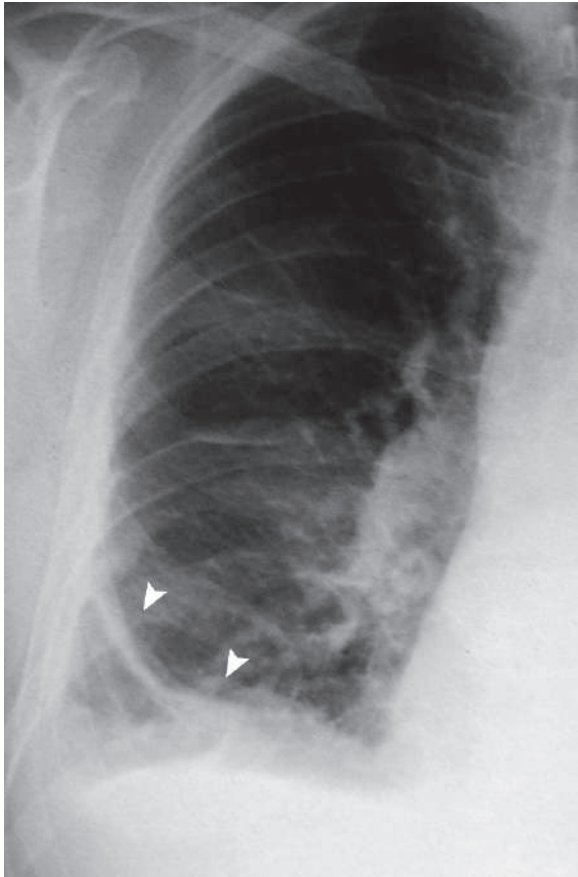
Posteroanterior plain chest radiograph shows plate atelectasis as thick radio-opaque shadow at the right costophrenic angle
